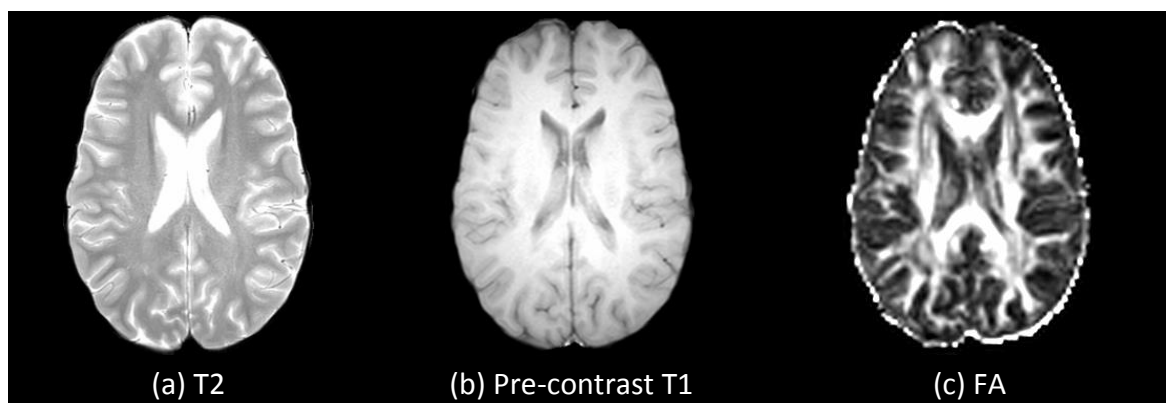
Comparison of white matter on T2, pre-contrast T1 and FA images. Images were acquired using a 1.5T MRI scanner (case MB622).
